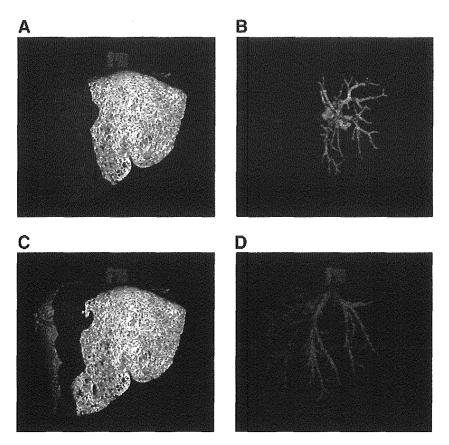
3D-CT image of a liver. The volume of each vessel branch can be automatically calculated before an operation using the new software. (A,B) Construction of a 3-dimensional image shows the perfusion area (orange color) of the right portal vein. (C,D) The construction of a 3-dimensional image shows the drainage area of middle hepatic vein (MHV) tributaries (V5, V8; indicated by red).
